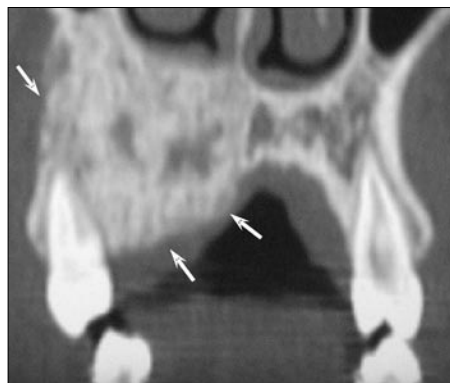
CT image (frontal view) of the same fibrous dysplasia seen in Figure 2a (courtesy of Dr. Carlos).
